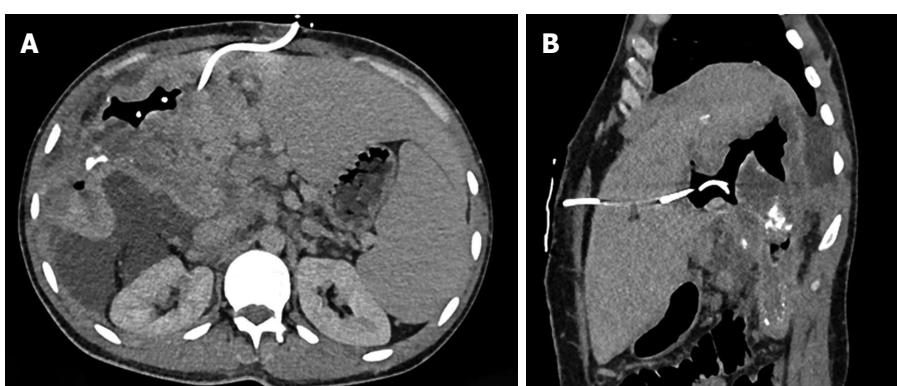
Non-contrast enhanced axial (A) and sagittal (B) computed tomography images show the percutaneous drainage of an infected parasitic cyst in a 43 year old woman with hepatic alveolar echinococcosis.
